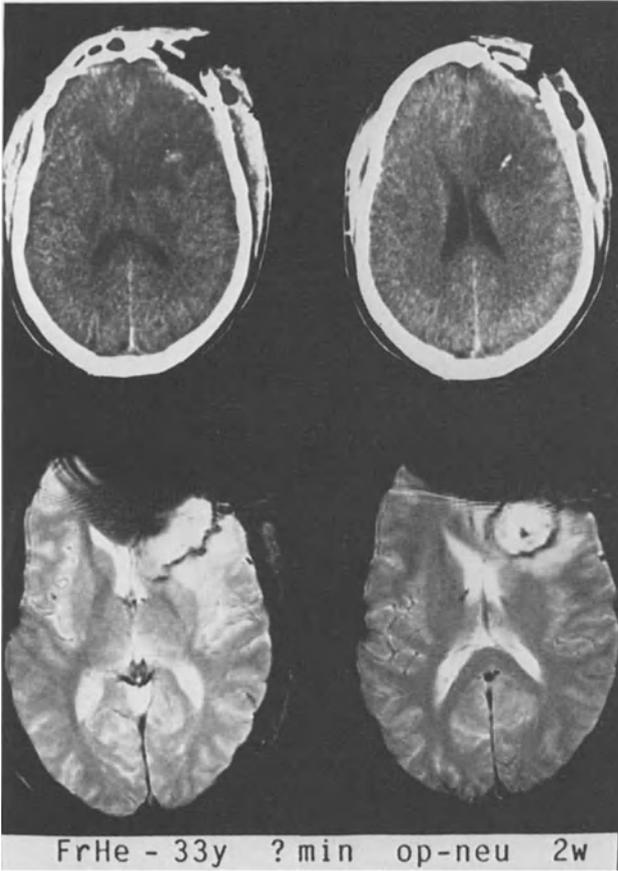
CT (above) and MRI (below) 2 weeks after operative removal of a bullet (muzzle-loader accident). CT: Postoperative state. Air artifacts (sinus frontalis opened by the bullet) and subgaleal swelling (partial volume effect) are seen. The hypodensity (frontal right) may correspond to a mixture of brain edema and isodense blood residua. One bone particle (hyperdense) is left in situ. MRI: Despite huge bifrontal artifacts (missile lesion and trephination), a part of the CT hypodensity can be identified as a bright area including a dark spot (bone) surrounded by a dark garland. The MRI scan alone could have been misinterpreted as showing space-occupying rebleeding. FrHe, initials; 33 y, age at the time of accident; 33 years; ? min, very short altered consciousness, probably seconds; apnea, neurosurgical emergency removal of the bullet by flap craniotomy; 2 w, outcome without neurological deficit at 2 weeks. EEG: pathological (theta-delta focus, frontal right)
